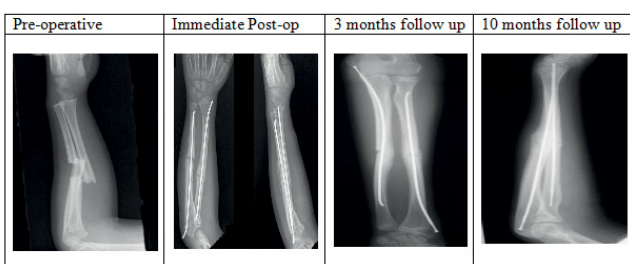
Radiographs of Forearm TENS.
